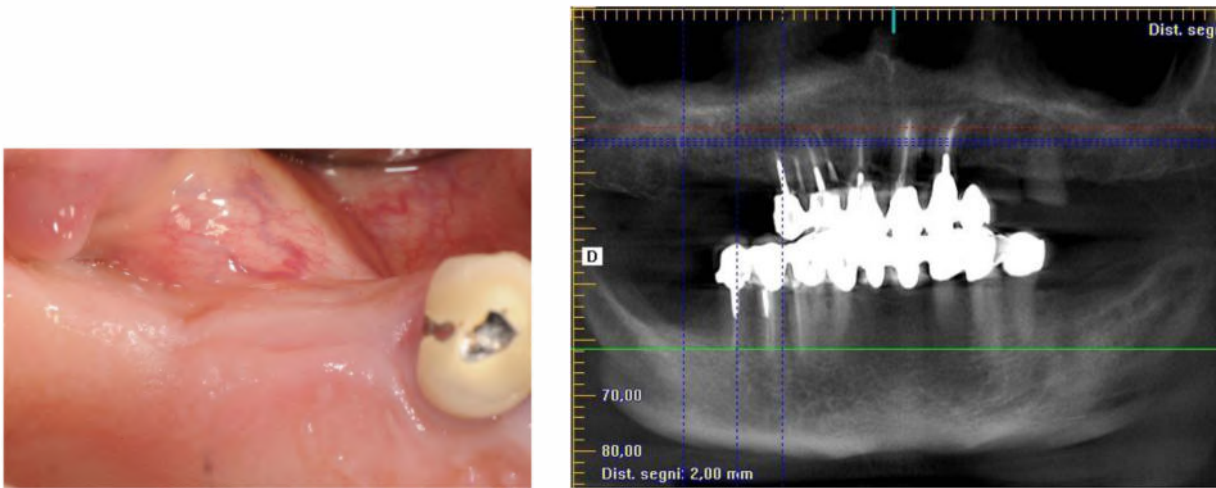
4 Clinical and radiographic aspect of edentulous ridge before treatment
